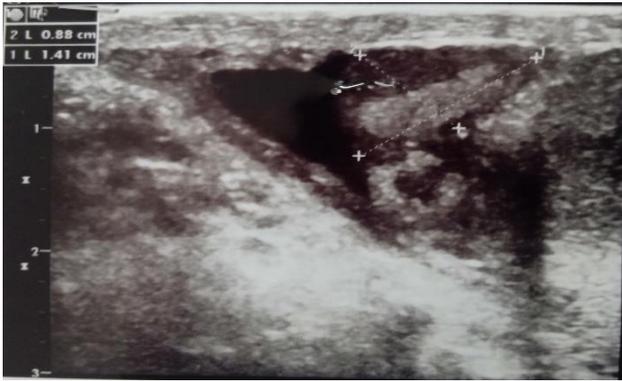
28 years old man with isolated tubercular epididymitis. Longitudinal sonogram of right hemi scrotum shows mildly altered echotexture of the epididymis with an echogenic focus within measuring 8x3 mm.
